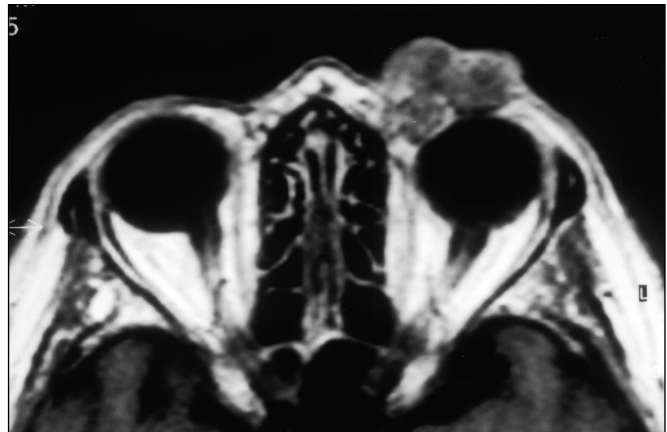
MRI scan showing extension of the tumor from the eyebrow into the upper nasal orbit to the equator of the eye globe.
